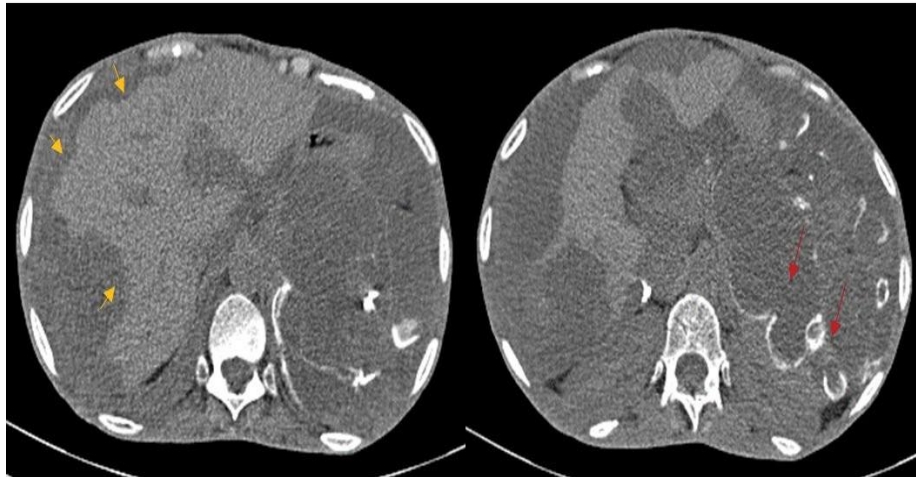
Axial abdominal CT on portal venous phase in a 45 year-old woman followed for mucinous neoplasm of the appendix showing pseudomyxoma peritonei, presenting as low attenuation ascites causing scalloping of liver surfaces (yellow arrow). Associated curvilinear calcifications are seen (red arrow).
